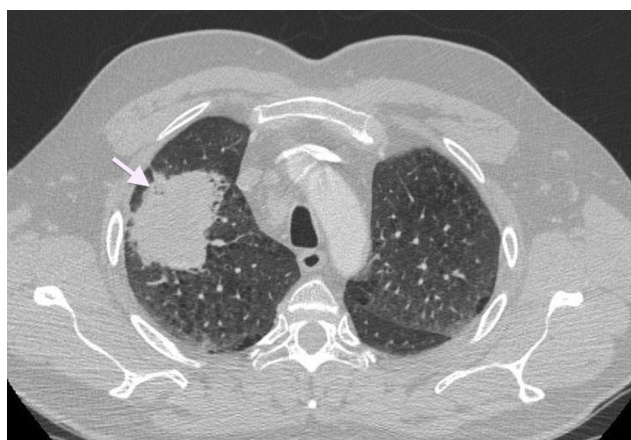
Parenchymatous-window thoracic CT, axial slices, with contrast medium injection.
